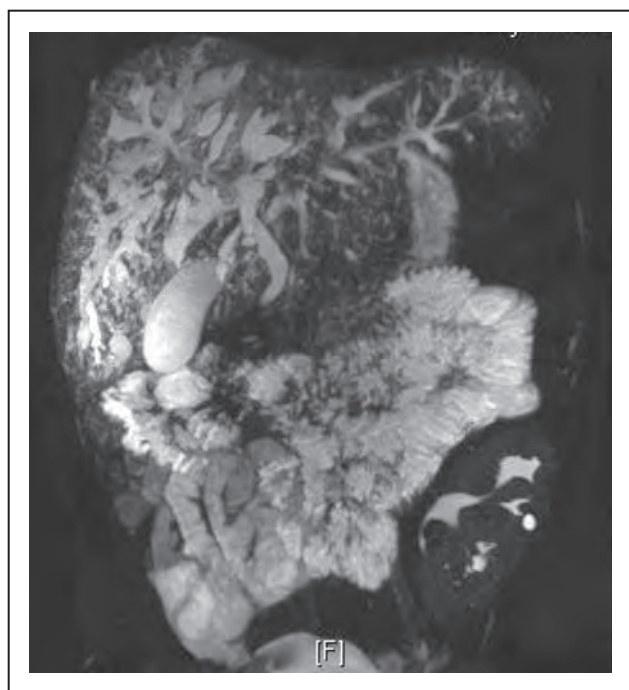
MRI of ARPKD–CHF with Caroli syndrome. Fusiform dilations of the intrahepatic biliary ducts. ARPKD, autosomal recessive polycystic kidney disease; CHF, congenital hepatic fibrosis. Reproduced with permission [8].
